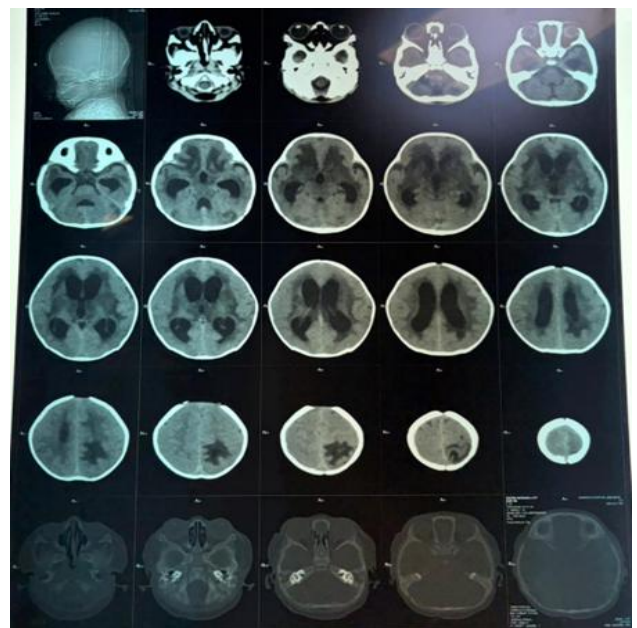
Axial CT brain showing marked dilatation of the lateral and third ventricles, suggestive of hydrocephalus.
